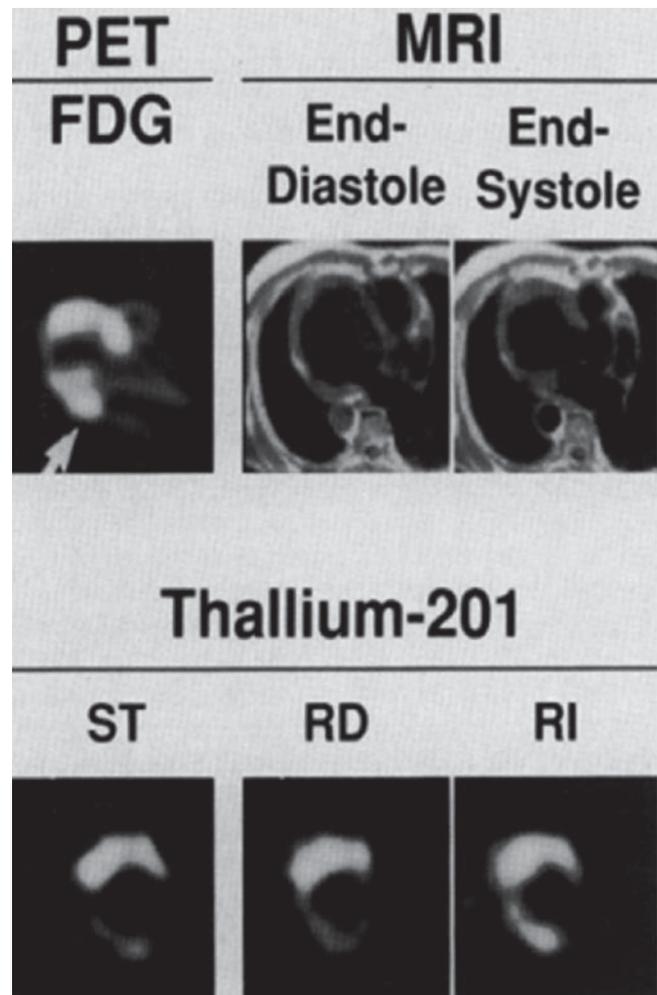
Abnormal myocardial region (arrow) with reduced FDG activity by PET, normal end-diastolic wall thickness, and presence of systolic thickening by MRI. SPECT images demonstrate a corresponding fixed defect on stress and redistribution images that improves after re-injection. *ST* stress; *RD* redistribution; *RI* re-injection. Reproduced from Perrone-Filardi et al.²⁷ with permission
